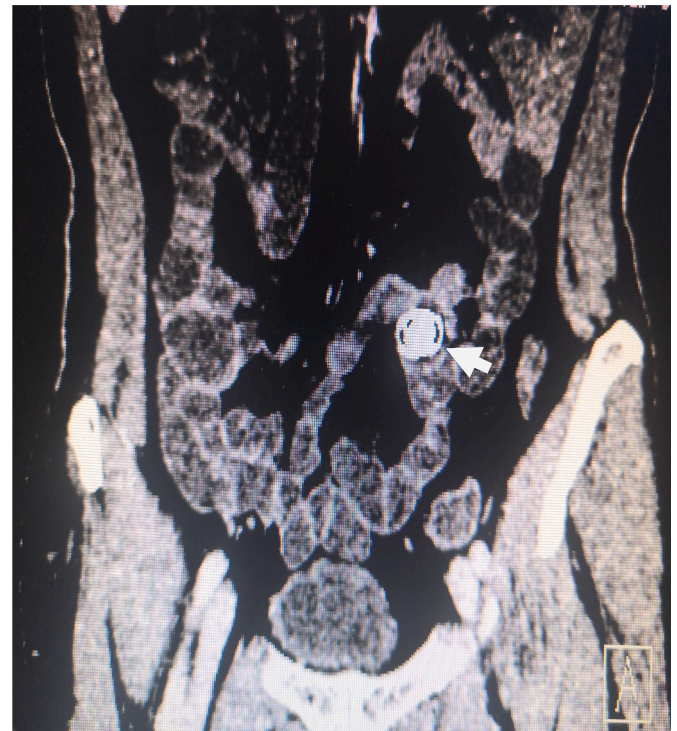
Examination of computed tomography enterography (CTE) showed slight thickening and enhancement of ileocecal region and part of ileum wall , dense shadows in small intestine of pelvic cavity (arrow).
